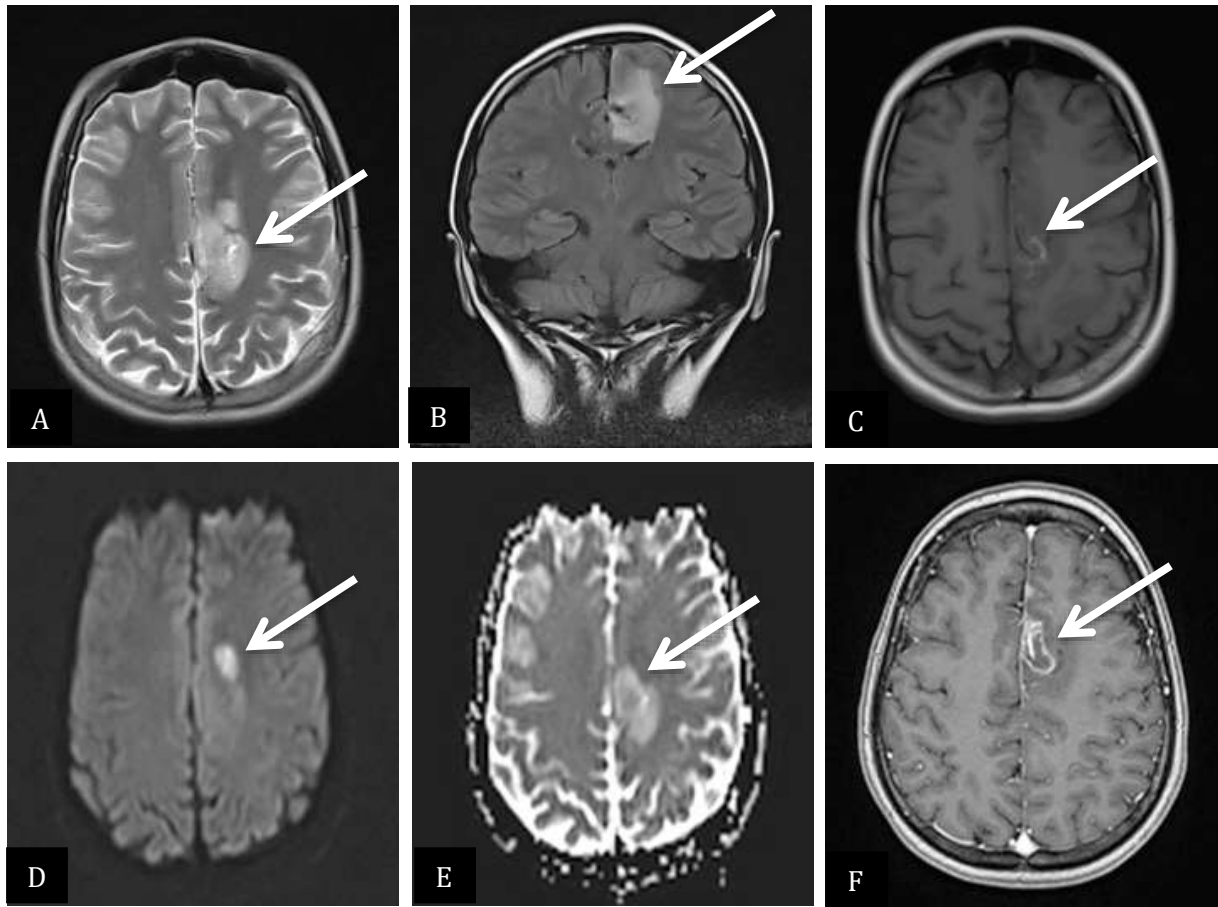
Case 1; 14yo/girl. (A) Axial T2W (B) Coronal FLAIR (C) Axial T1W (D) Axial DWI (E) Axial ADC (F) Axial T1 Post-gadolinium. There is a rim enhancing lesion in the grey white matter - junction at parasagittal region of the left high fronto-parietal region which demonstrates low signal intensity on T1W, high signal intensity on T2W and restricted diffusion on DWI/ADC suggestive of tuberculous abscess (arrow). There is associated adjacent white matter and cortical edema as well as leptomeningeal enhancement
